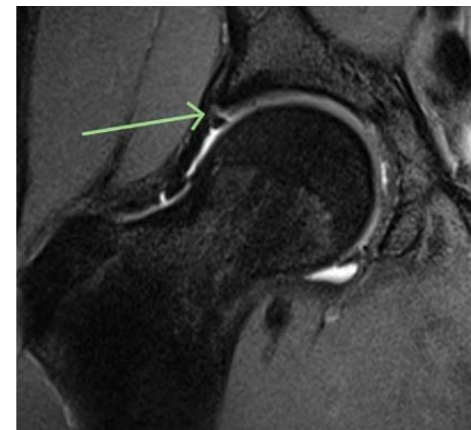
MRI Coronal PD fat suppressed. Acute superolateral labral tear with a full thickness fluid cleft undermining the labrum.
